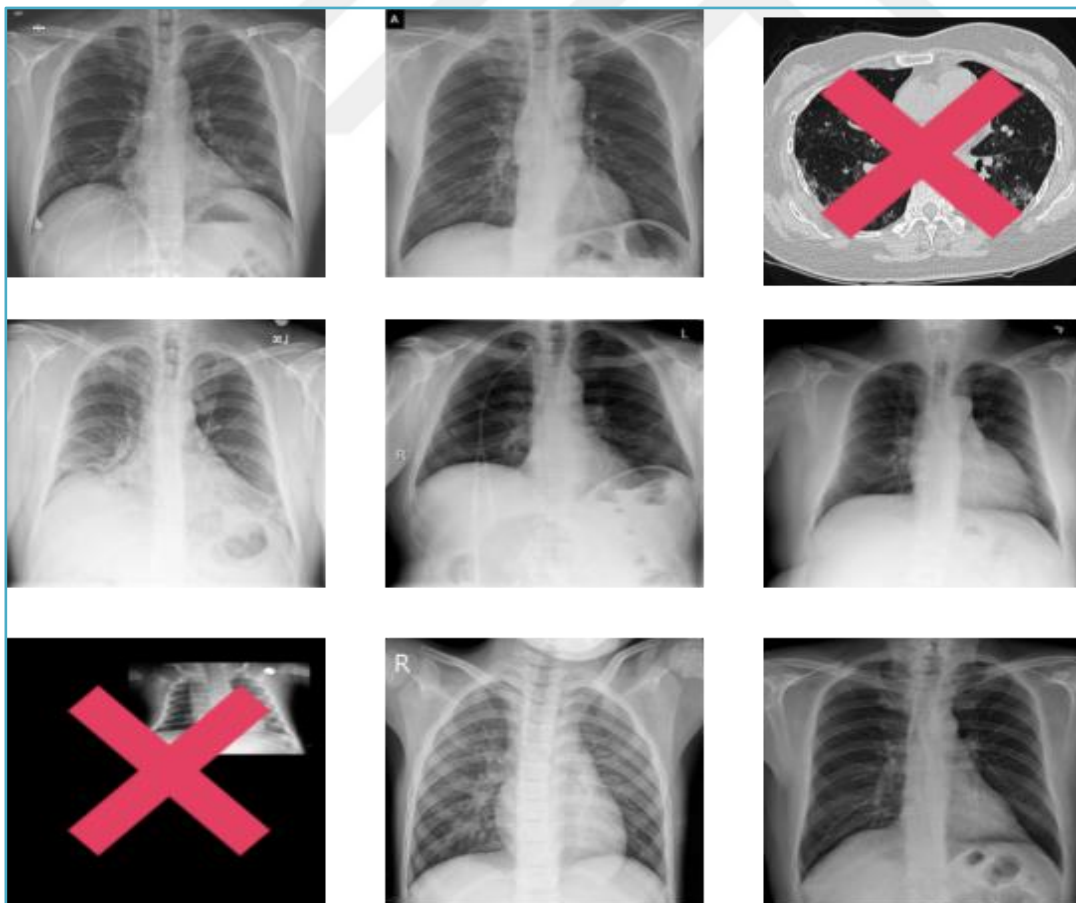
Chest X-Ray And CT Scan images in the data cleaning phase.
